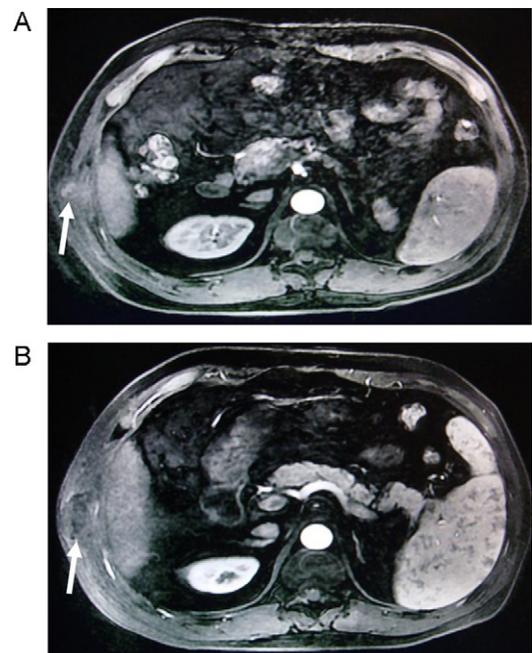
A 53-year-old man with needle tract seeding after percutaneous microwave ablation of deep hepatocellular carcinoma, who was previously performed biopsy for three insertions. (A) Transverse contrast-enhanced MRI shows hyperintensity 19-mm diameter seeding nodule (arrow) in the subcutaneous soft tissue 6 months after MWA in arterial phase. (B) Contrast-enhanced MRI shows hypointensity HIFU treatment zone (arrow) for seeding lesion in arterial phase.
